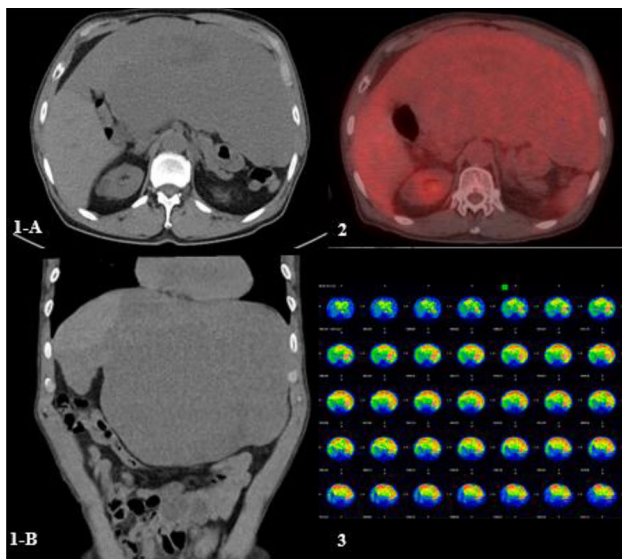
A-P CT scan (without enhance) showed 25cm sized huge hepatic mass in the Lt. lobe.
